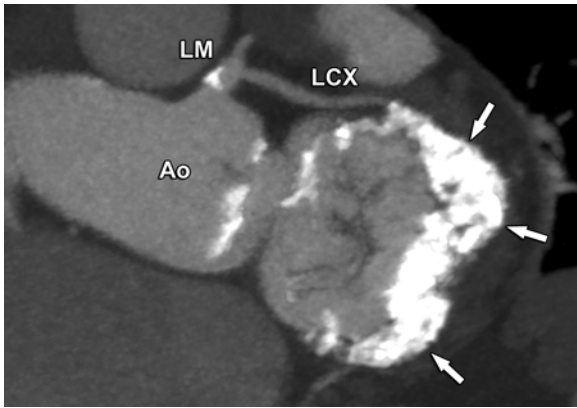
Severe mitral annulus calcification as seen by CT. The posterior part of the mitral annulus is frequently calcified in old patients. The *arrows* indicate large calcifications of the posterior mitral annulus, which may be a contraindication to indirect transcatheter indirect mitral annuloplasty. CT short-axis images are very useful to assess this aspect. *Ao* aorta, *LCX* left circumflex coronary artery, *LM* left main coronary artery
